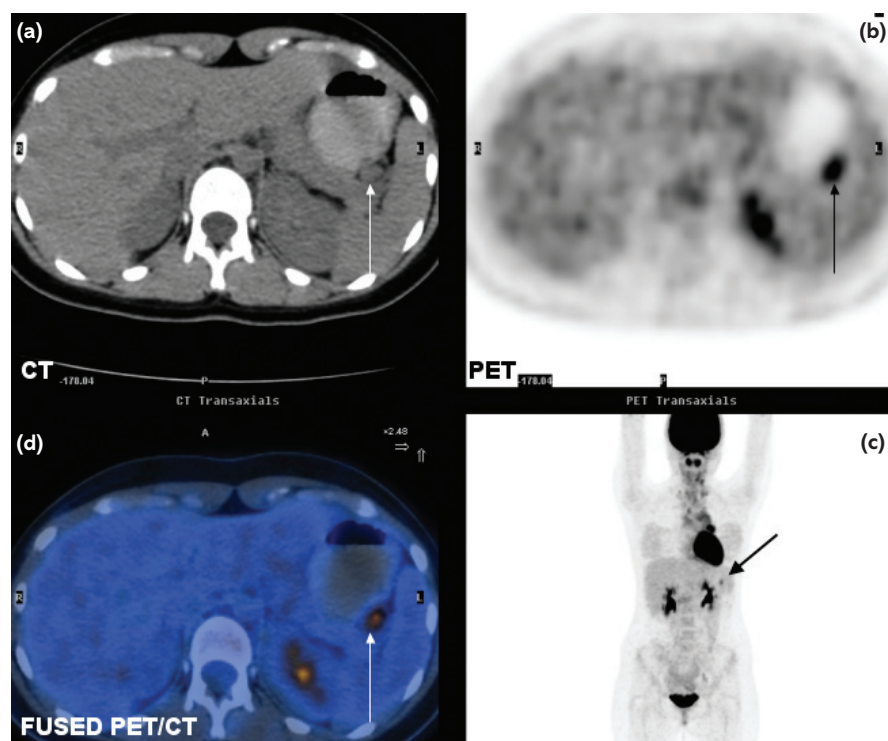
A 13-year-old boy with newly diagnosed non-Hodgkin's lymphoma, showing multiple sites of abnormal ^{18}F -fluorodeoxyglucose (FDG) uptake in cervical and mediastinal lymph nodes. On (a) computed tomography (CT) alone and (b) and (c) positron emission tomography (PET) alone it is impossible confidently to localise the focus of FDG activity (arrow) in the upper abdomen; (d) combined PET/CT clearly demonstrates that FDG uptake here is due to a lymph node adjacent to greater curve of stomach. In this case, the PET/CT finding leads to upstaging of lymphoma from stage II to stage III.
